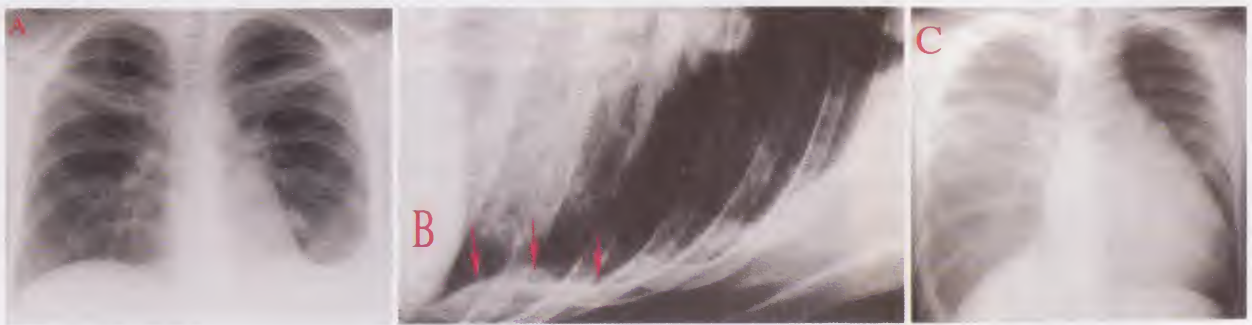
Three plain chest x-rays; PA view (A) showing blunting of the left costo-phrenic angle and meniscus sign, left lateral decubitus view (B) showing free pleural effusion collecting along the dependent lateral costal margins, and portable supine view (C) showing homogenous increased density of the right hemithorax
